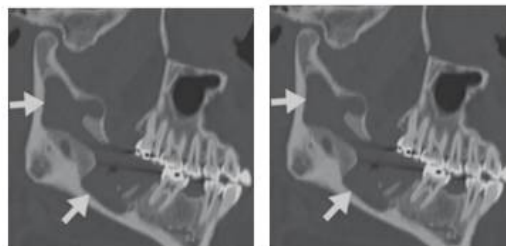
Keratocystic odontogenic tumor. (A) Oblique sagittal CT image demonstrates large radiolucent mass (arrows) in posterior body of mandibular ramus, with scalloping of cortex. (B) Axial contrast-enhanced CT image demonstrates cystic mass with mild peripheral enhancement (arrow) breaking through cortex and extending into left masseter muscle.
